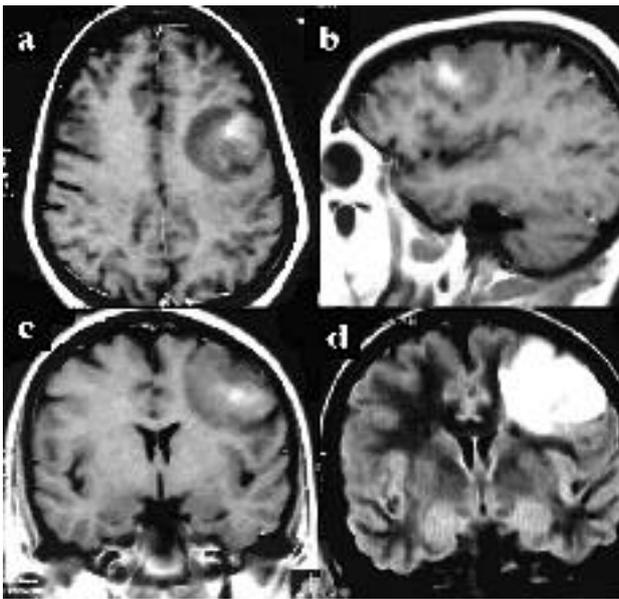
MRI of a patient that showing a contrast-enhancing mass that turned out to be LGG on resection.
